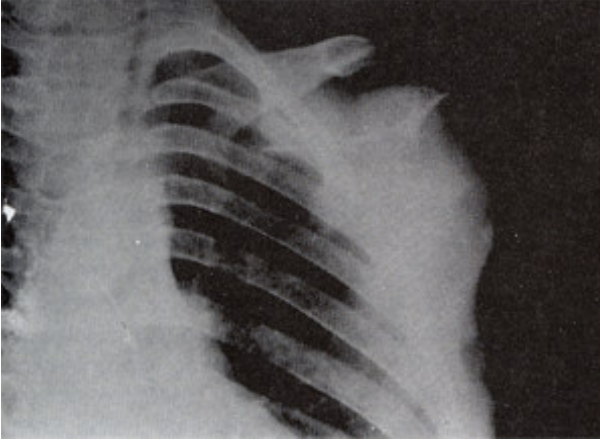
Preoperative X-ray of the patient.
